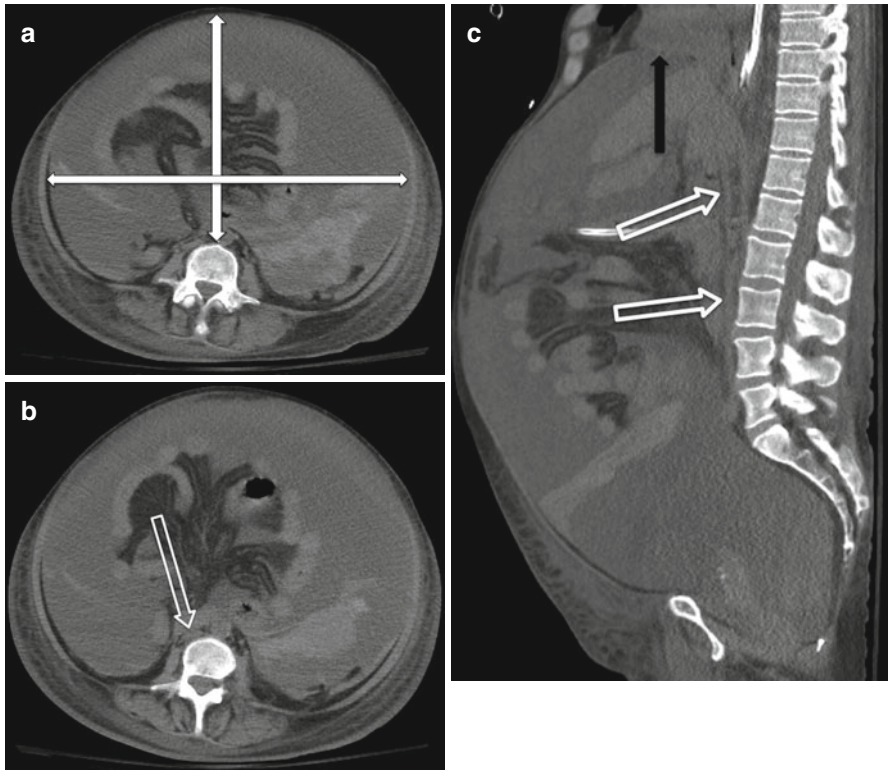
Non-contrast CT was performed due to renal failure, which shows high-attenuating peritoneal fluid, consistent with hemoperitoneum and increased AP-to-transverse dimension ratio (*double-headed arrows*) of 0.7 (a). The axial (b) and sagittal (c) images show collapsed inferior vena cava (*open arrows*). An elevated right hemidiaphragm can also be seen (*black arrow*) (c)
